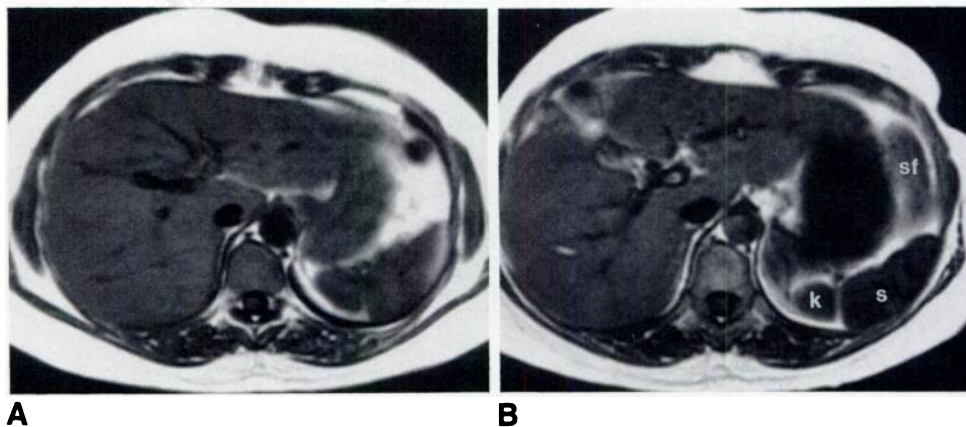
Axial T1-weighted MR images of duodenum/pancreas.
